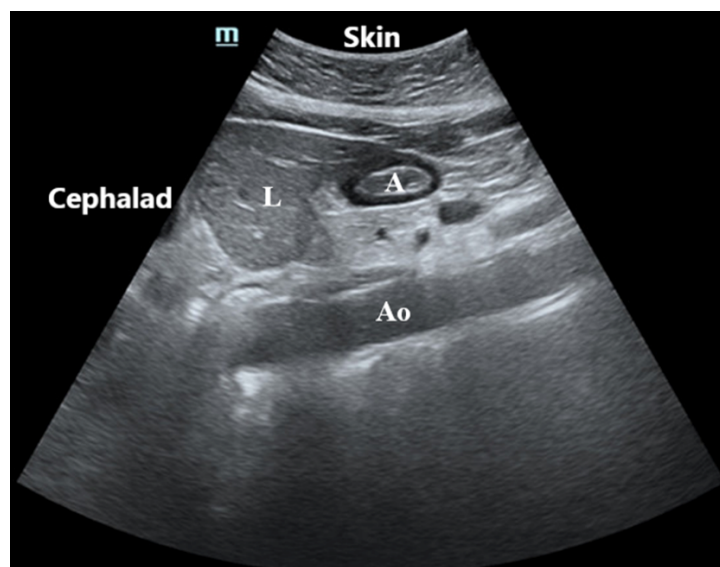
Ultrasound measurement of the antral section. A = gastric antrum; L = liver; Ao = aorta.
